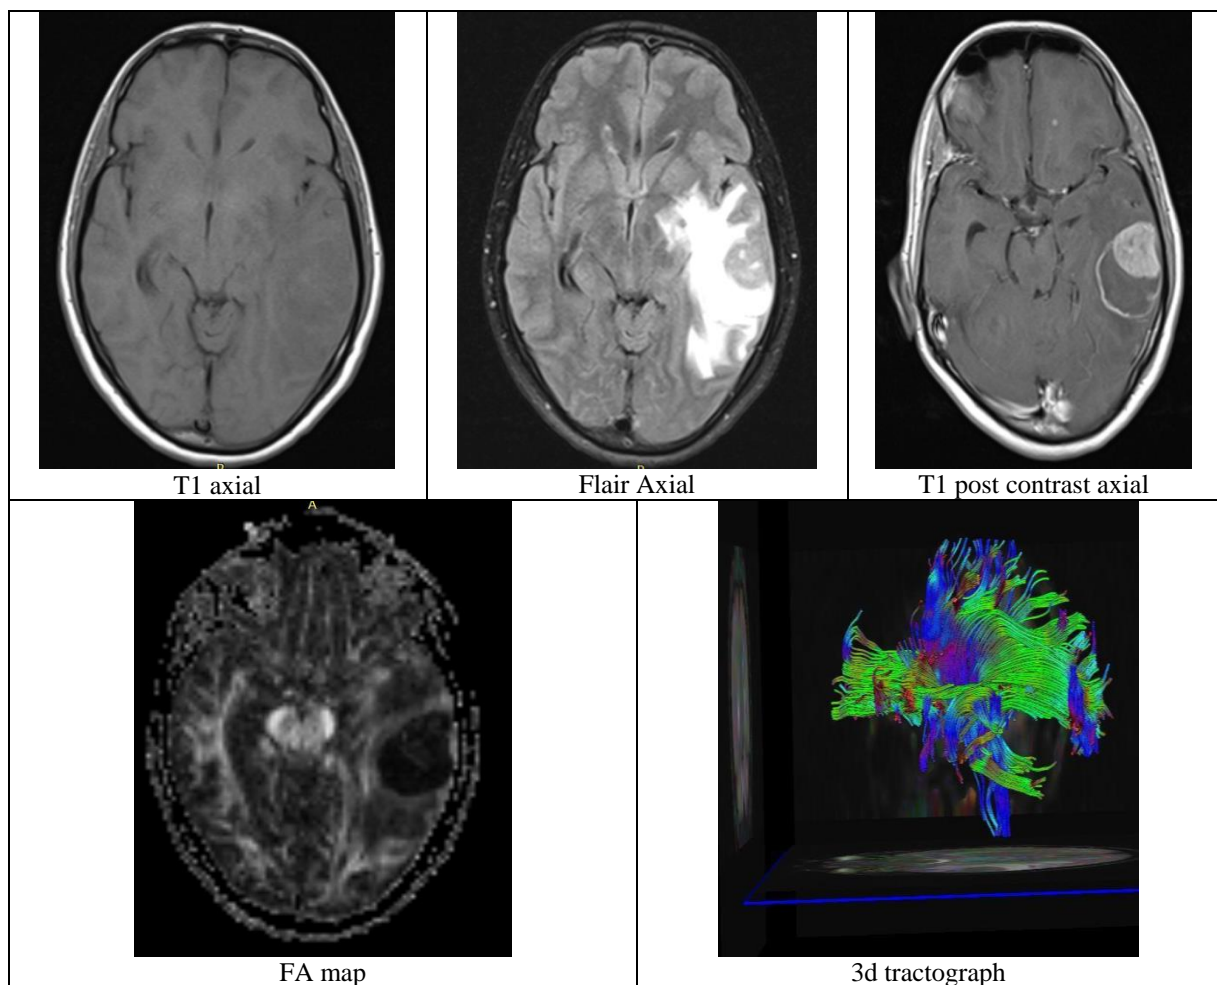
A 36 year old male patient with known case of malignant lesion in right hilar region of lung and brain metastases: MRI shows welldefined T1 hypointesne FLAIR heterogeneously hyperintense lesion in left temporal lobe, with moderate perilesional edema. Post contrast enhancement is noted. DTI shows edematous peritumoral white matter tracts, increase in ADC in edema $1.6 \pm 0.04 \times 10^{-3} \text{ mm}^2/\text{sec}$, as compared to contralateral white matter $0.78 \pm 0.02 \times 10^{-3} \text{ mm}^2/\text{sec}$.
